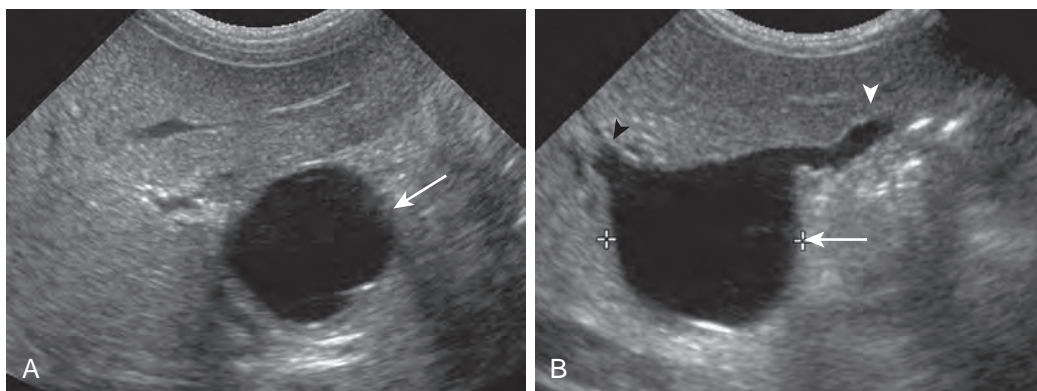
Choledochal malformation: cystic type. A and B. Ultrasound images obtained on the third day of life show the small gallbladder (white arrowhead) that empties into the choledochal cyst (arrow). At surgery, the cyst was amputated proximally at the common hepatic duct (black arrowhead).
